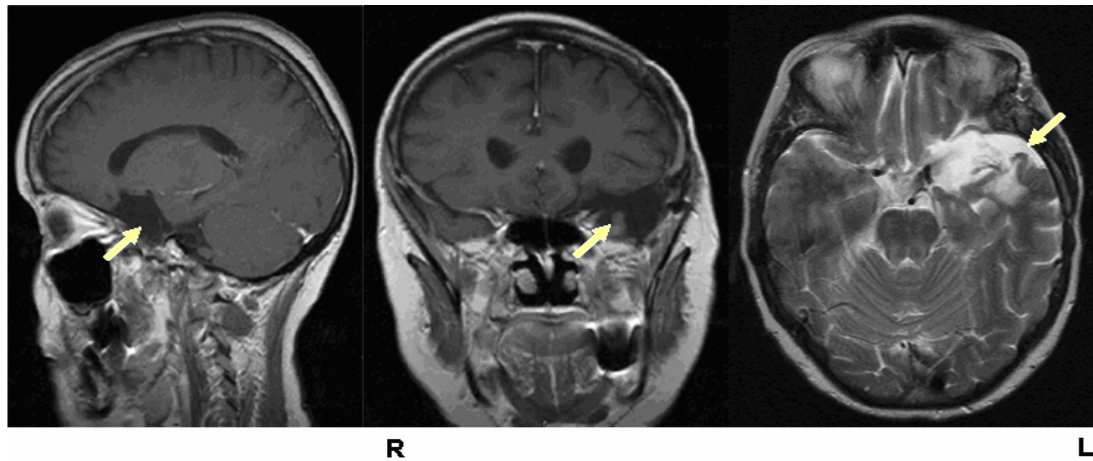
ES's 3 month follow-up MRI scan. Arrows indicate the area of resection and oedema.
